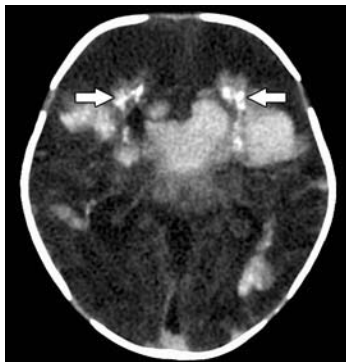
Brain CT scan of family IV, patient 1, showing periventricular and basal ganglia calcifications in addition to enlargement of the left lateral ventricle.
